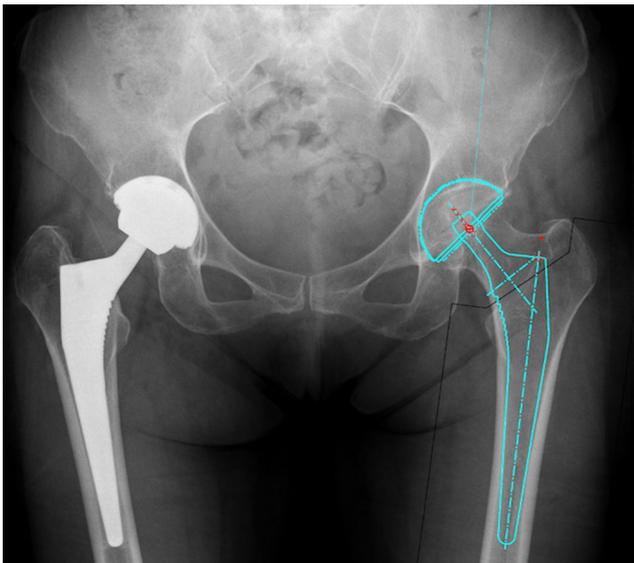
One-year post-operative radiograph. The non-injured side was templated for demonstration
